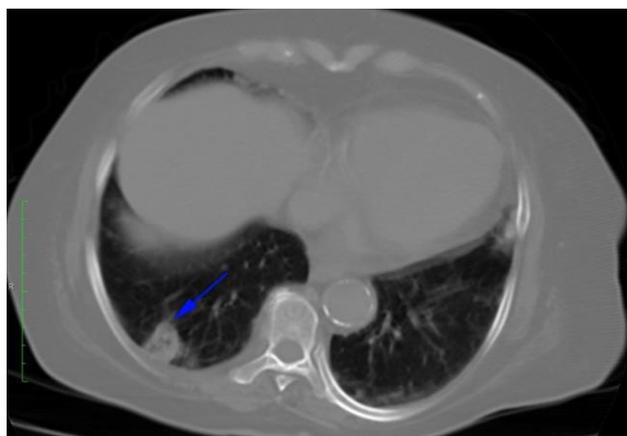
Septic pulmonary embolism image at thorax CT on admission.
